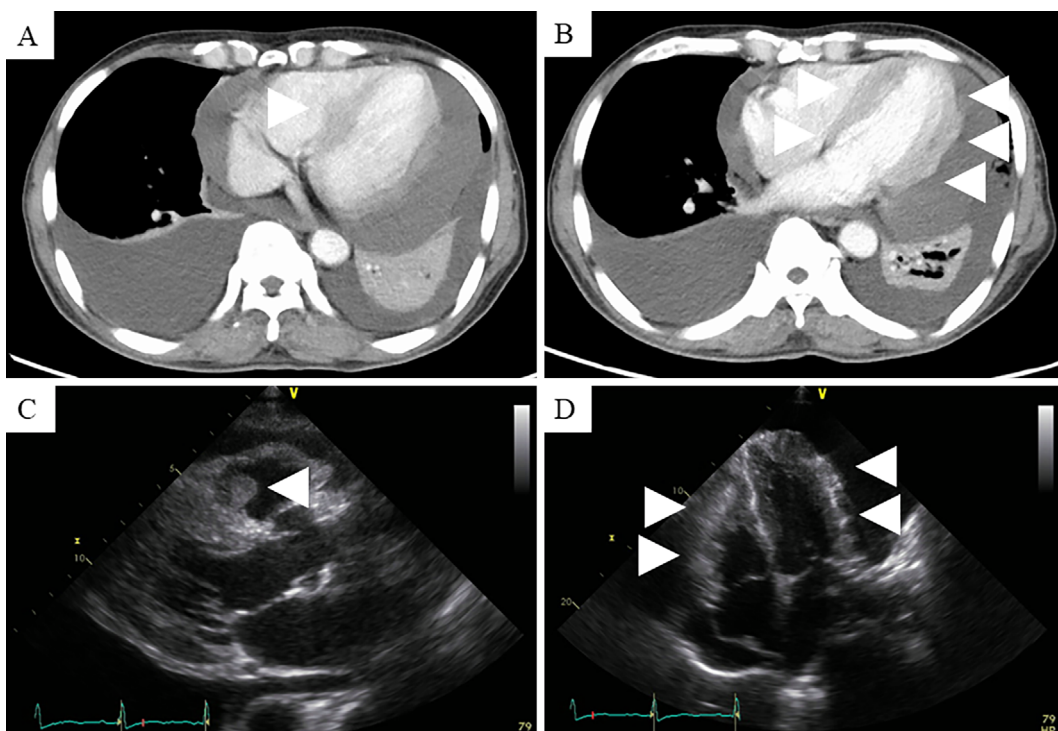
CT and TTE findings in the heart at the time of the detection of cardiac metastases. Contrast-enhanced CT revealed a tumor with a poor enhancement in the ventricular septum (A; arrowhead) and heterogeneous wall thickening of the left ventricle (B; arrowheads) along with pericardial effusion (A, B). TTE showed that the mass originated from the ventricular septum and protruded into the right ventricle lumen on a parasternal long-axis tomogram (C; arrowhead), and diffuse wall thickening of the left and right ventricle was noted on an apical 4-chamber tomogram (D; arrowheads).
